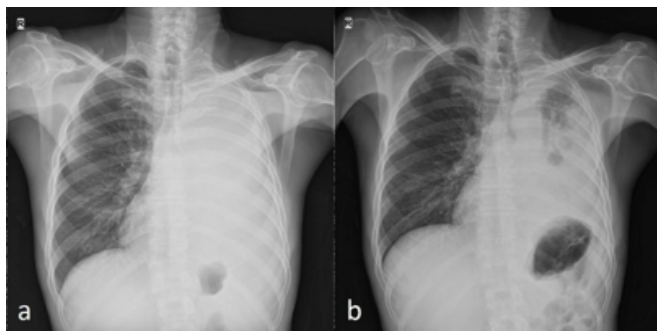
Chest X-ray showing the total atelectasis of the left lung (a), the partial ventilation was seen on the left lung after bronchoscopic tumor destruction (b).
